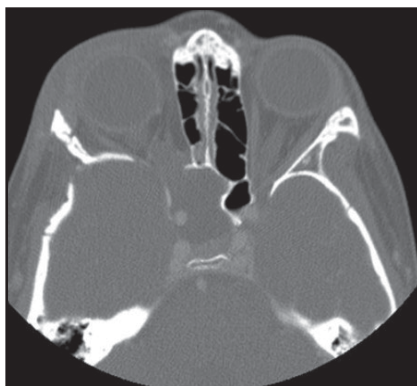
Sphenoid wing dysplasia. Axial CT image in bone window reveals anterior displacement and thinning of the sphenoid bone on the right with enlargement of the middle cranial fossa in the anteroposterior dimension. A soft tissue mass extending through and expanding the right optic canal, consistent with an optic pathway glioma, is partially seen.
